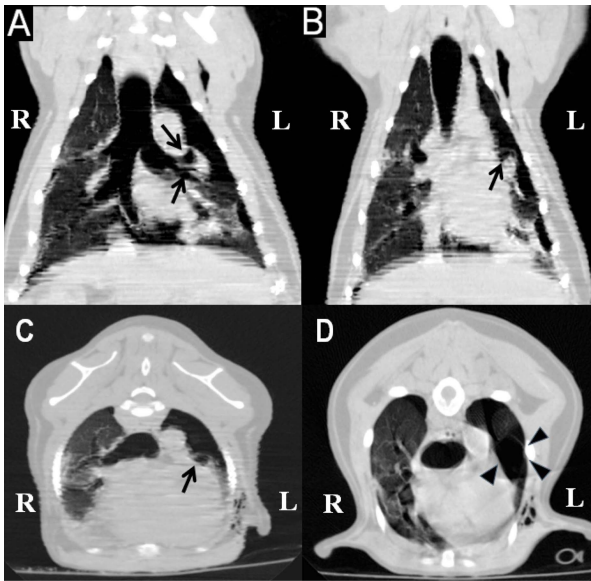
Dorsal (A, B) and transverse (C, D) CT images. Note the collapsed lobe with abnormally non-tapered end of bronchus (arrows) and probable bullae (arrow heads) at the left cranial lobe.
